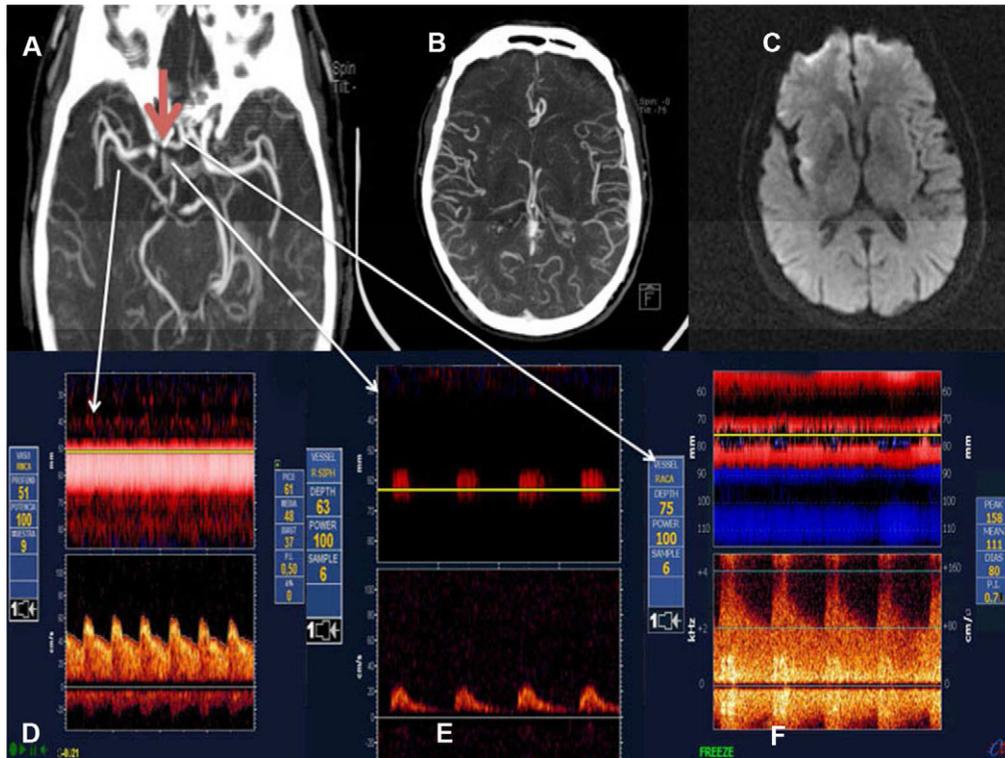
Case 19, 78-year-old male, arrived within 30 minutes of symptom onset of a right side MCA stroke. Initial NIHSS score of 2 points. (A) CTA interpreted as normal by the neuroradiologist on call; the red arrow demonstrates a short right terminal carotid occlusion. (B) CTA demonstrates symmetrical filling of both MCA territories, which may be due to collateral flow. (C) DWI showing small insular ischemic changes. (D) TCD at the beginning of thrombolysis demonstrates a middle cerebral artery with good flow velocity but with low pulsatility index suggesting post stenotic flow, and a proximal vascular lesion. (E) Occlusion of right terminal carotid as revealed by the TCD. (F) Inverted, high velocity flow in the right anterior cerebral artery compatible with anterior cross filling (collateral flow).
